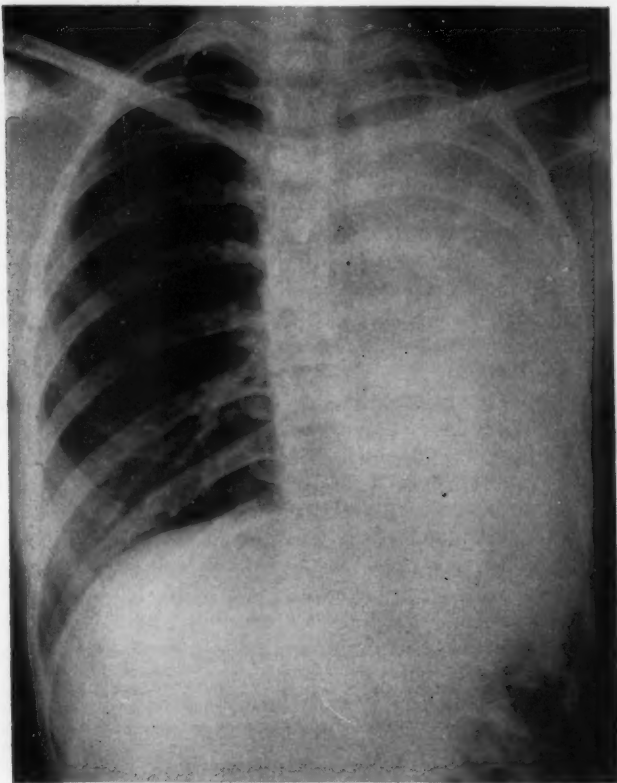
Case 1. Roentgenogram of the chest showing evidence of collapse of left lung with herniation of right upper lung into left chest.
